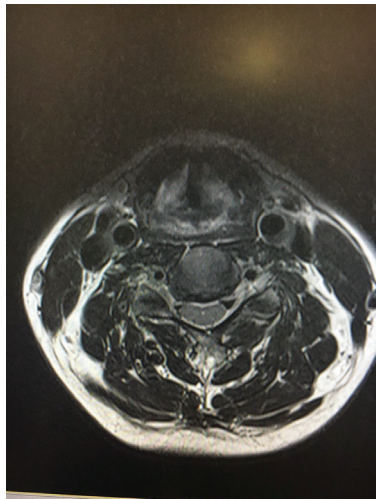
MRI cervical spine axial view C4-5 level.
